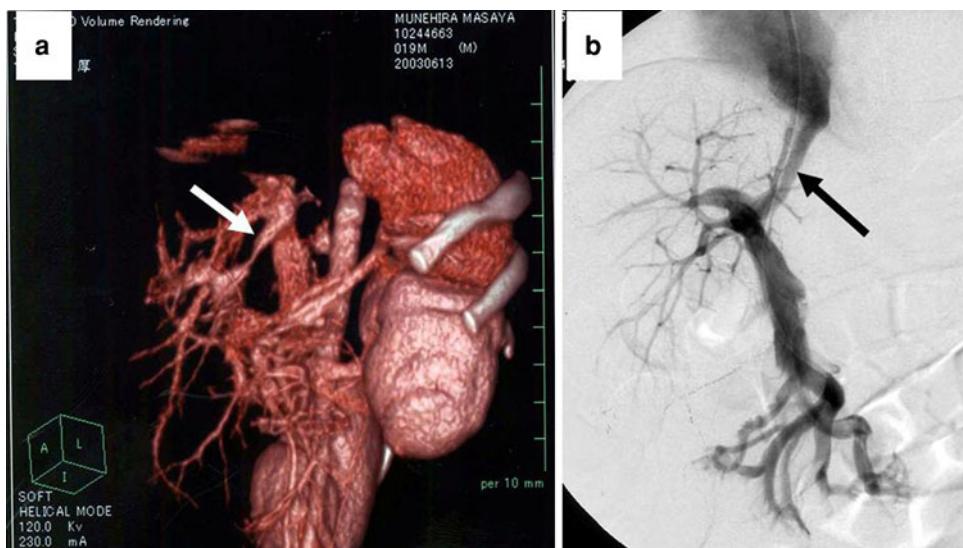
CT angiography with 3D reconstruction in case 2 (1-year-old boy) with clearly visible patent ductus venosus (a). This is a similar grade as portal venography via the superior vena cava (b)
